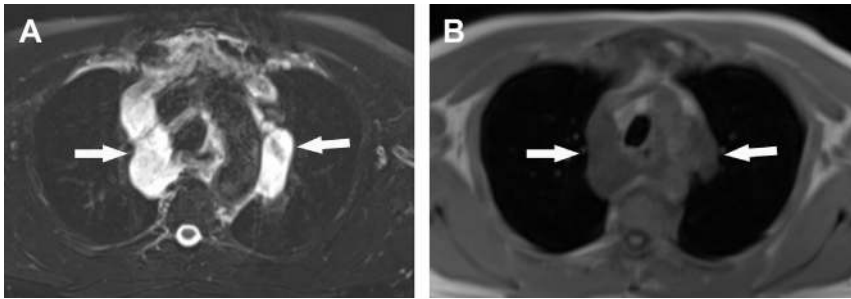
MRI features of patient with mediastinal lymphangioma (arrows). (A) Axial T2-weighted MRI shows high signal pretracheal and paratracheal masses. The high signal is due to high water content in lymphangiomas. (B) The signal on T1-weighted image is similar to smooth muscle.
